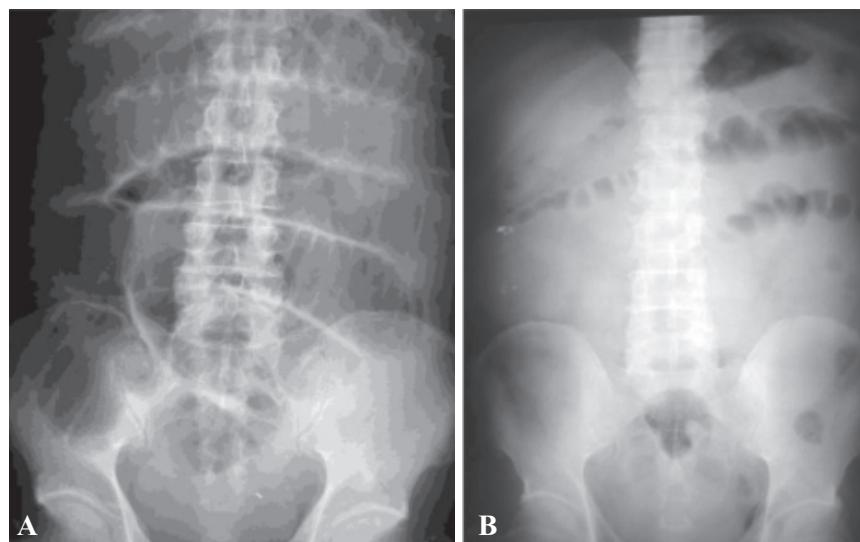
A. Step-ladder pattern of SBO; supine abdominal radiograph shows multiple dilated loops of small bowel, lying layer by layer, similar to multiple steps of the ladder.
